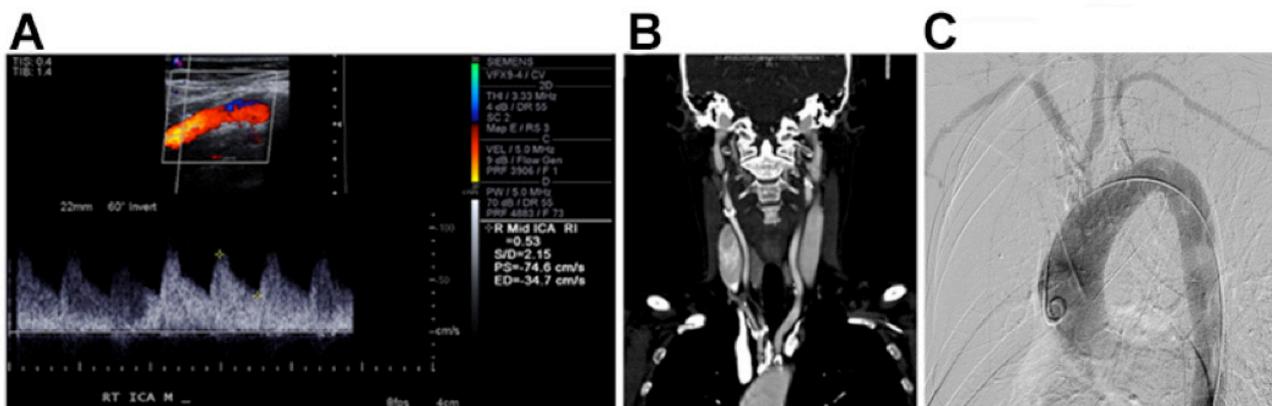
This patient's carotid artery duplex ultrasound (A) showing normal carotid artery waveforms and velocities, (B) computed tomography angiogram showing supra-aortic trunk vessel lesions, and (C) aortic arch angiography with heavy atherosclerotic burden in the supra-aortic trunk vessels.
